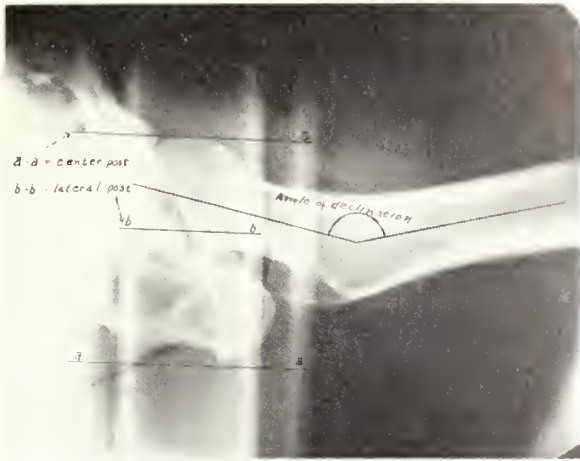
Lateral x-ray view (note that shadow of lateral post is centered between the walls of center post).
